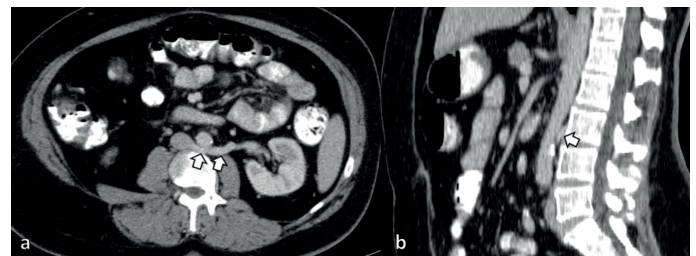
On axial MPR and sagittal contrast enhanced abdomen CT images (a, b) you can see retroaortic left renal vein (white arrows).
